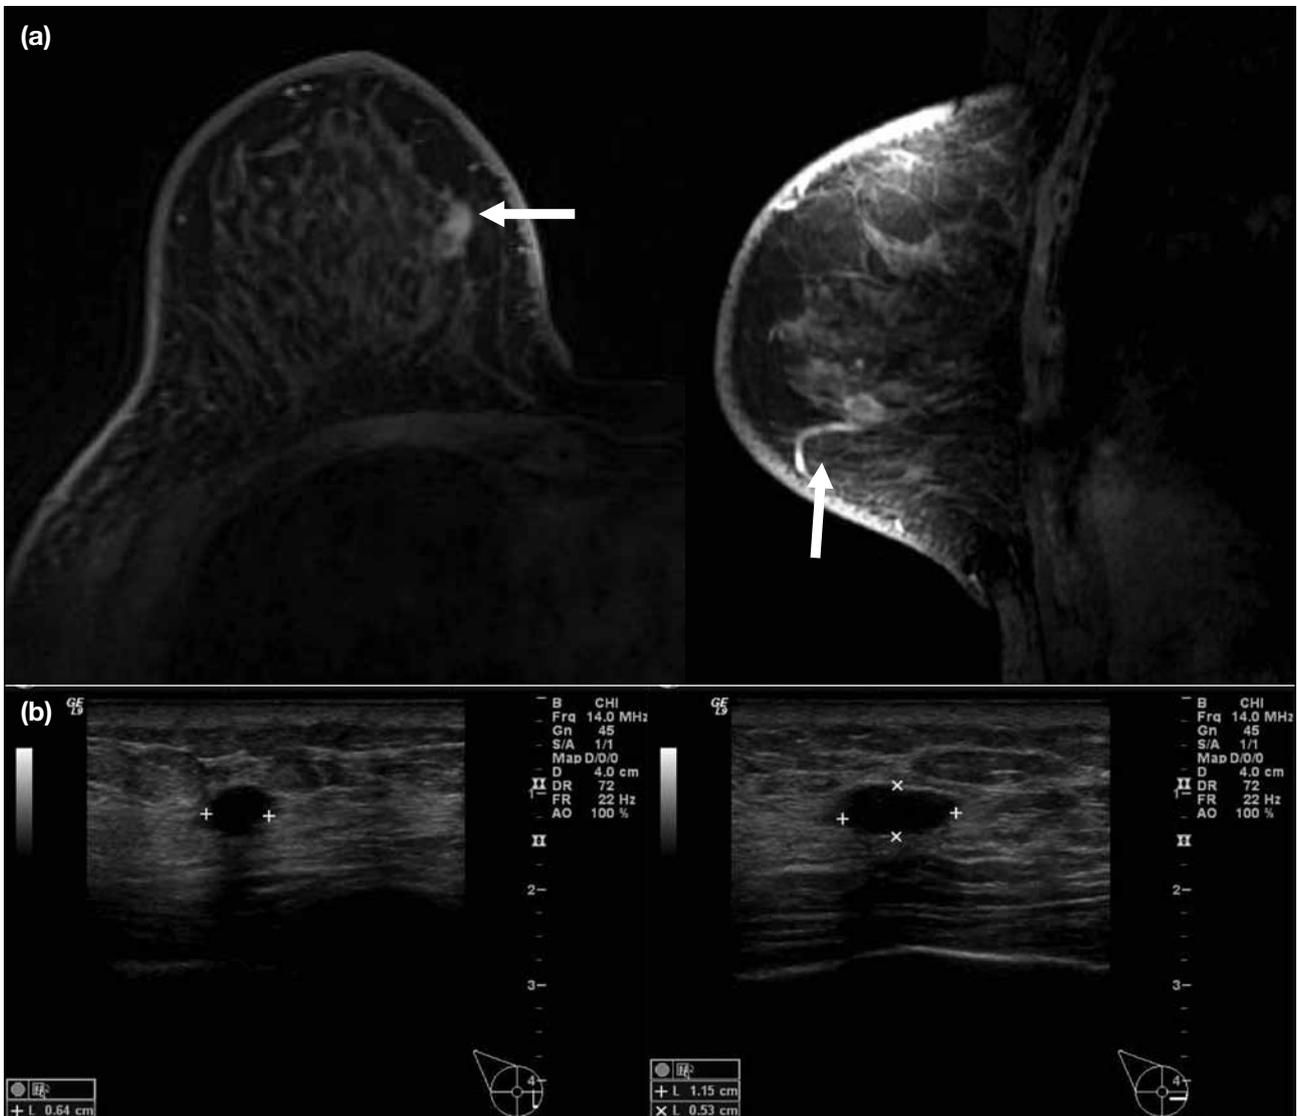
This patient with a history of carcinoma of breast and left mastectomy, was found to have right metastatic axillary lymph nodes of breast in origin. Private mammography and ultrasound of the right breast were normal. (a) Axial and sagittal contrast-enhanced T1-weighted subtracted images show an abnormal peripheral rim-enhancing mass at the inner lower quadrant of right breast (arrows). (b) A second-look ultrasound reveals the corresponding mass outlined by calipers.
